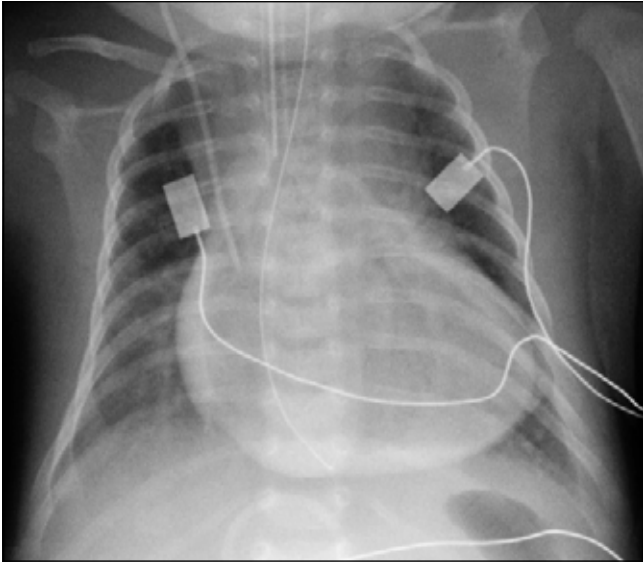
Follow up chest radiograph after removal of the left subclavian line and insertion of a new right-sided internal jugular vein catheter. Contrast is seen filling the pericardial sac, outlining the heart.
